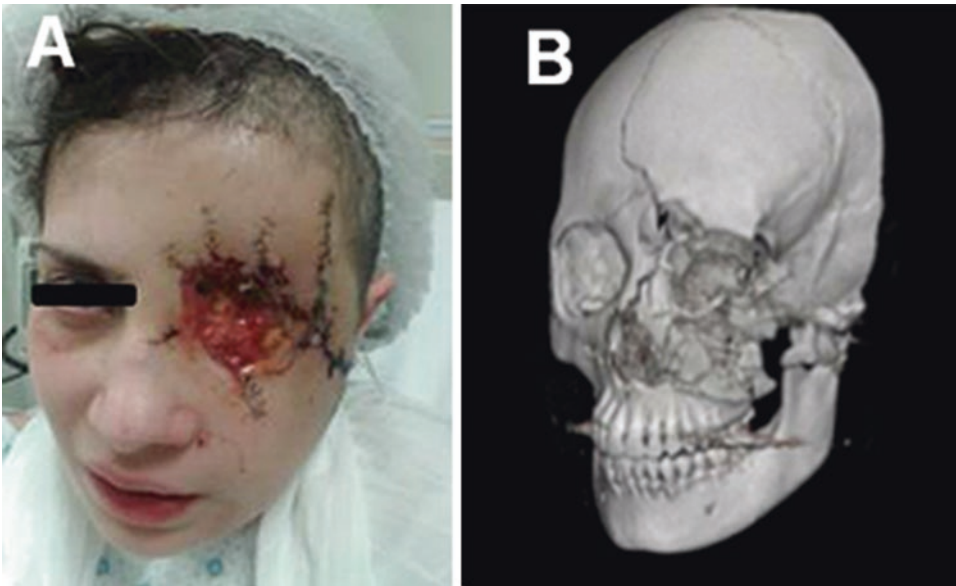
Initial presentation (a) and CT scan (b)
